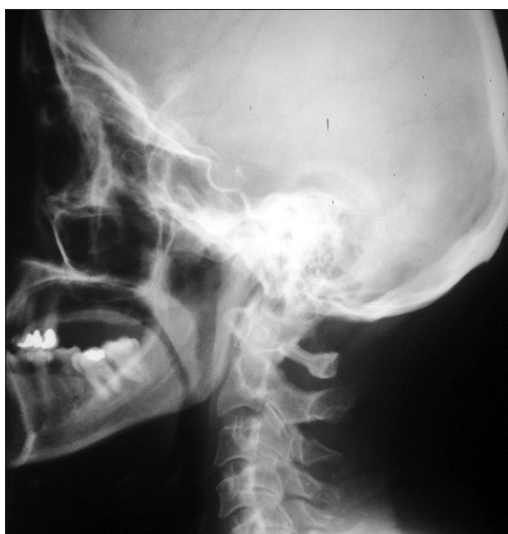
A lateral skull and neck X-ray shows increased length of the styloid process.
